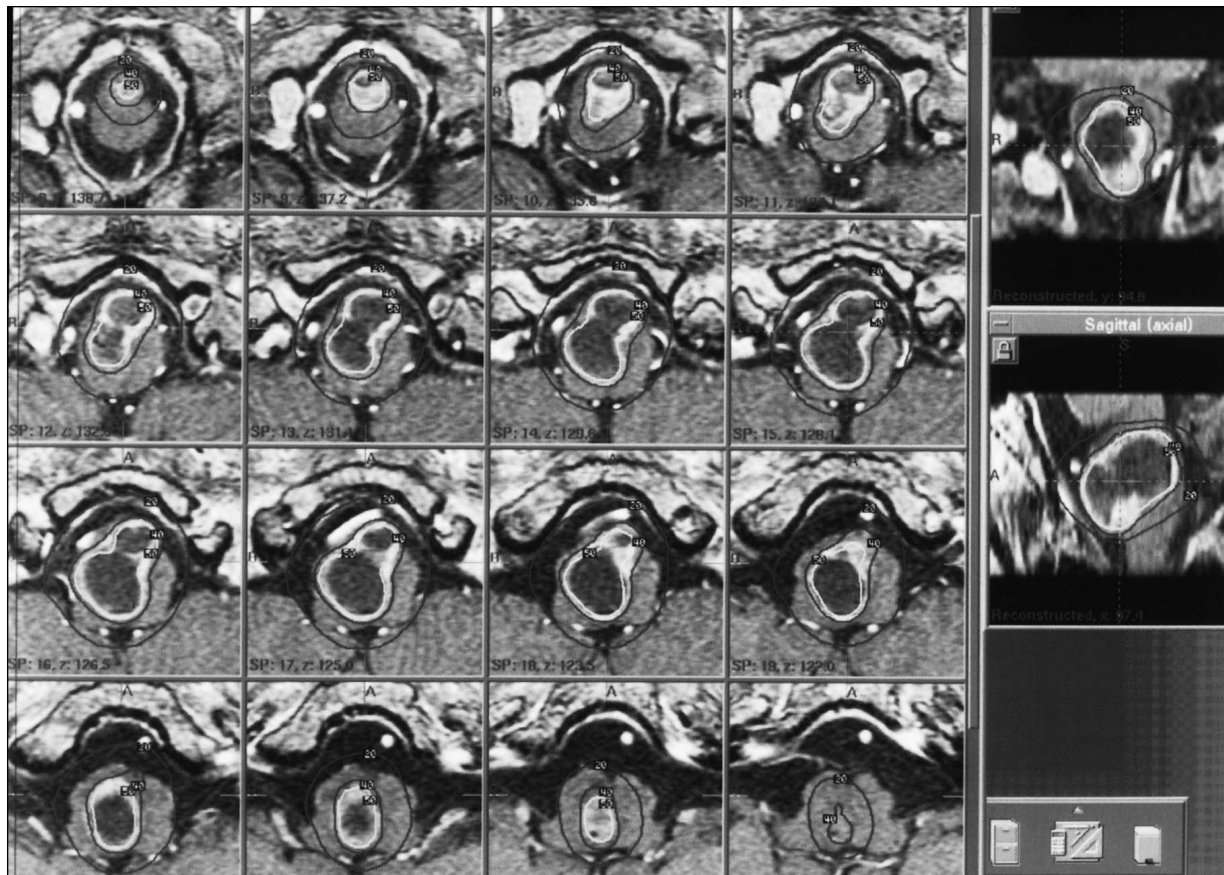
C: A radiosurgery plan for cystic medullary tumor immediately after partial stereotactic aspiration. The 50%, 40%, and 20% isodose lines are shown in axial MR images with sagittal and coronal reconstructions.
